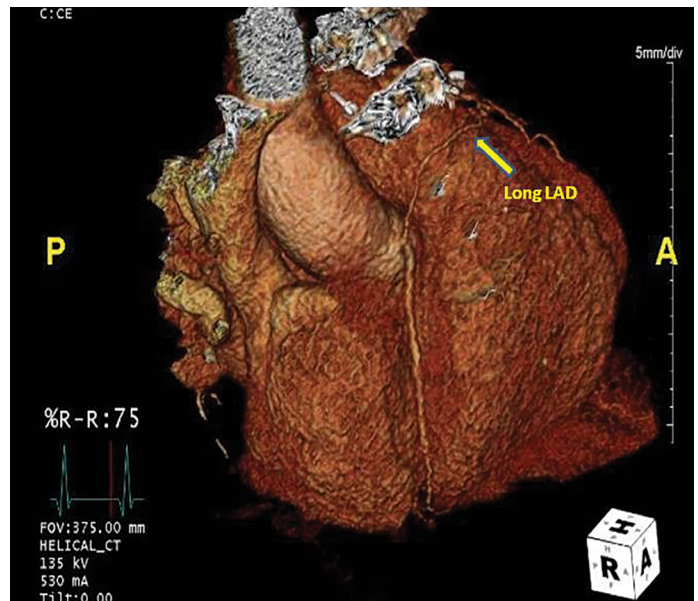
Three-dimensional volume-rendered computed tomography angiography image shows right coronary artery and long left anterior descending artery originated from right coronary sinus
